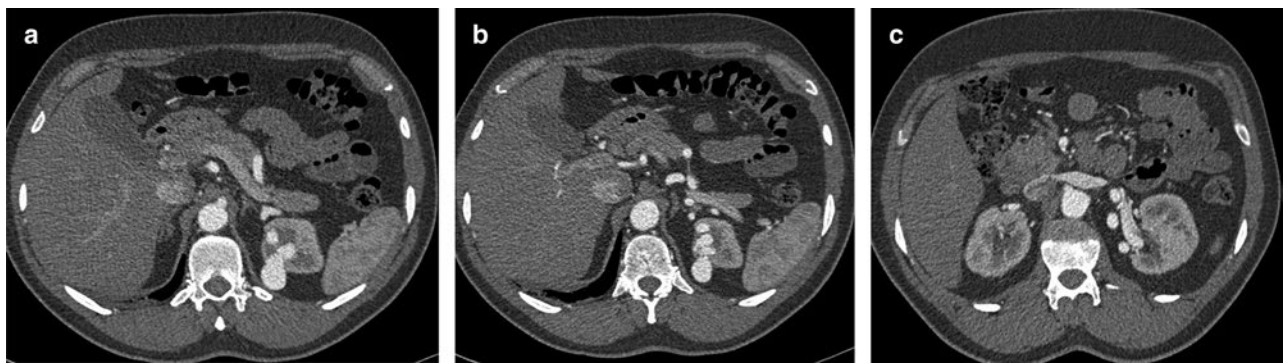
(a–c) Computed tomography angiogram (CTA) demonstrates renal arteriovenous fistula with aneurysmatic dilatation.
